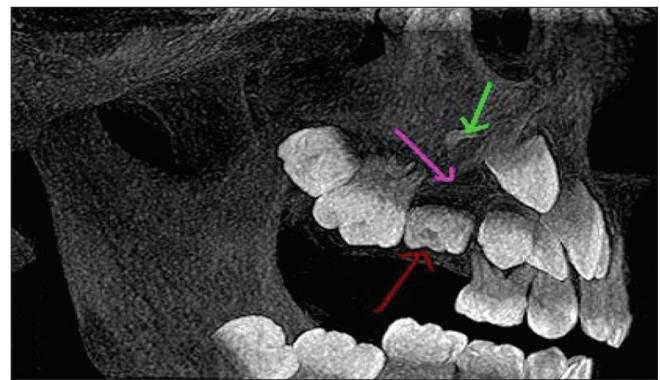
Right lateral cone-beam computed tomography image showing the remaining palatal root (green arrow) and the slight occlusal movement of the permanent second premolar (red arrow) 3 months after surgical removal of the odontoma, the cystic lesion and the second maxillary deciduous molar (pink arrow)
